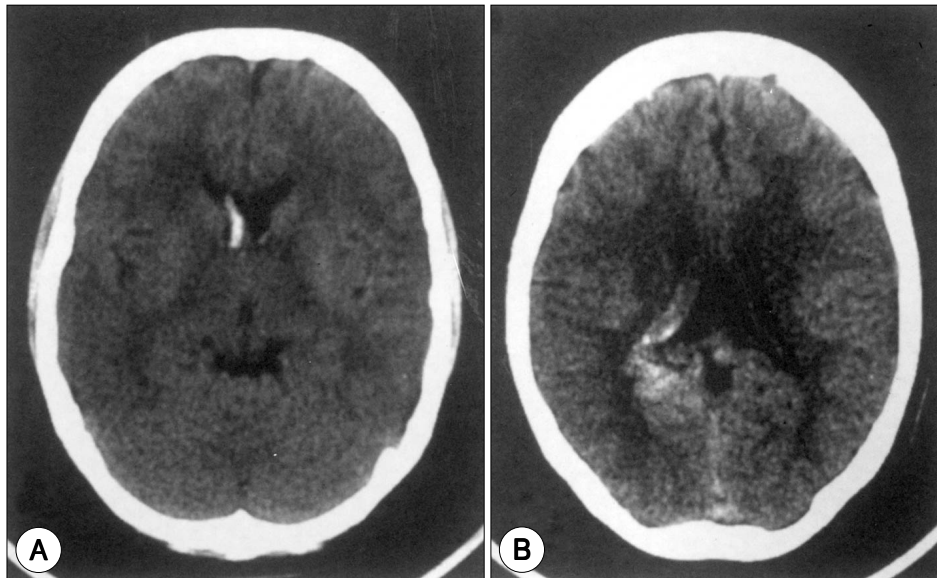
Preoperative computed tomography showing hemorrhage on the frontal horn of the lateral ventricle(A) and enhanced mass lesion on the parasplenial-subtrigonal area(B).
